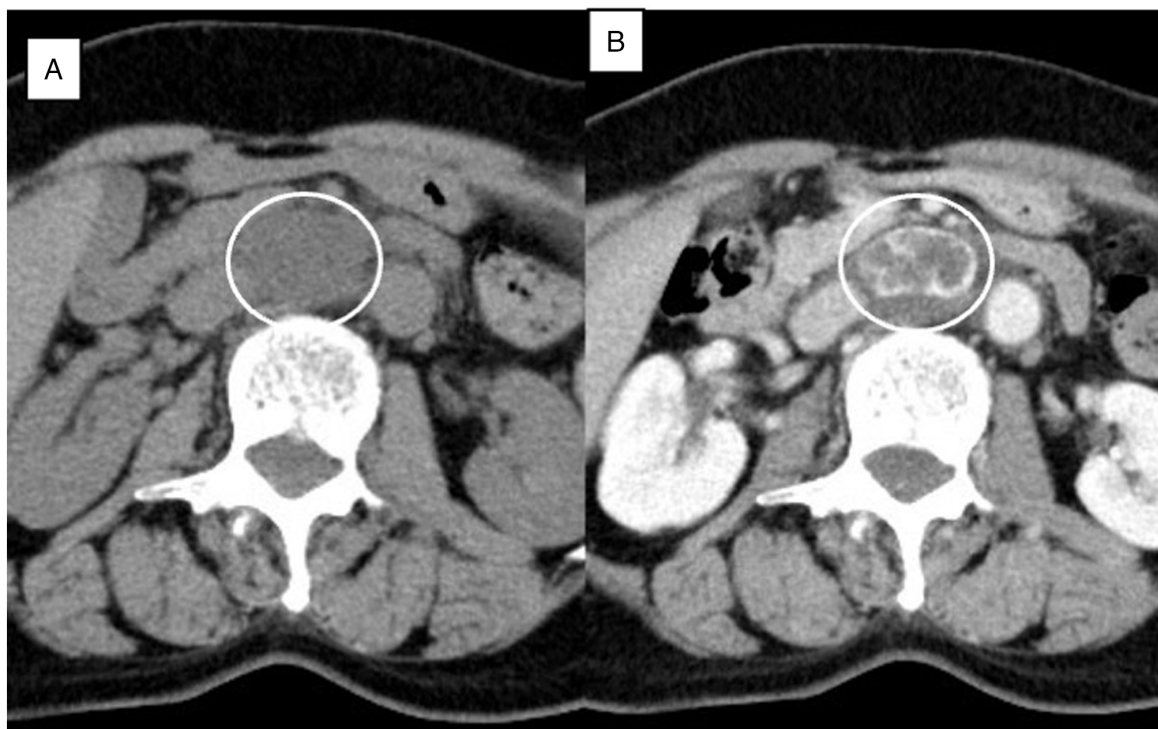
Abdominal CT scan after 4 years. The white circle indicates the retroperitoneal tumor. (A) Non-contrast-enhanced CT scan. (B) Contrast-enhanced CT scan in the portal phase. The tumor gradually increased to a maximum diameter of 35 mm.
